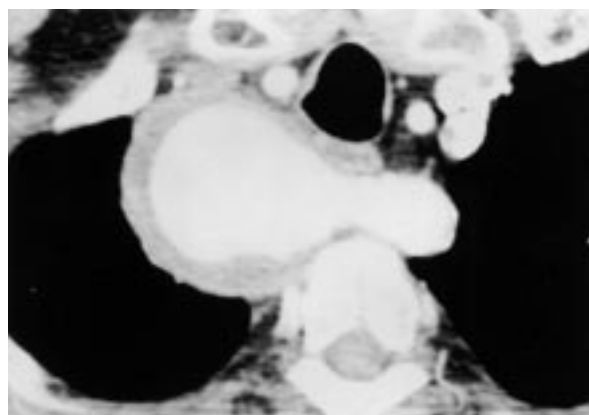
Computed tomography scan shows the aberrant right subclavian artery passing posterior to the trachea and esophagus, becoming aneurysmal to the right of the midline. Maximal diameter of the aneurysm is 5.4 cm.
